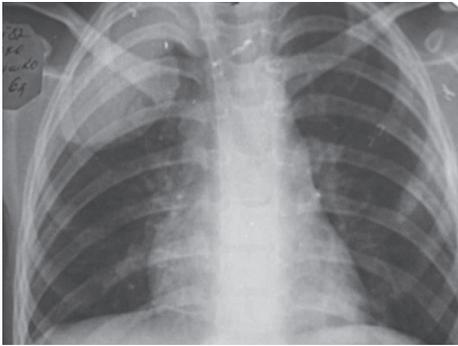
Two-projection review radiography of a 6-year-old girl with congenital solitary cyst of the right lung
